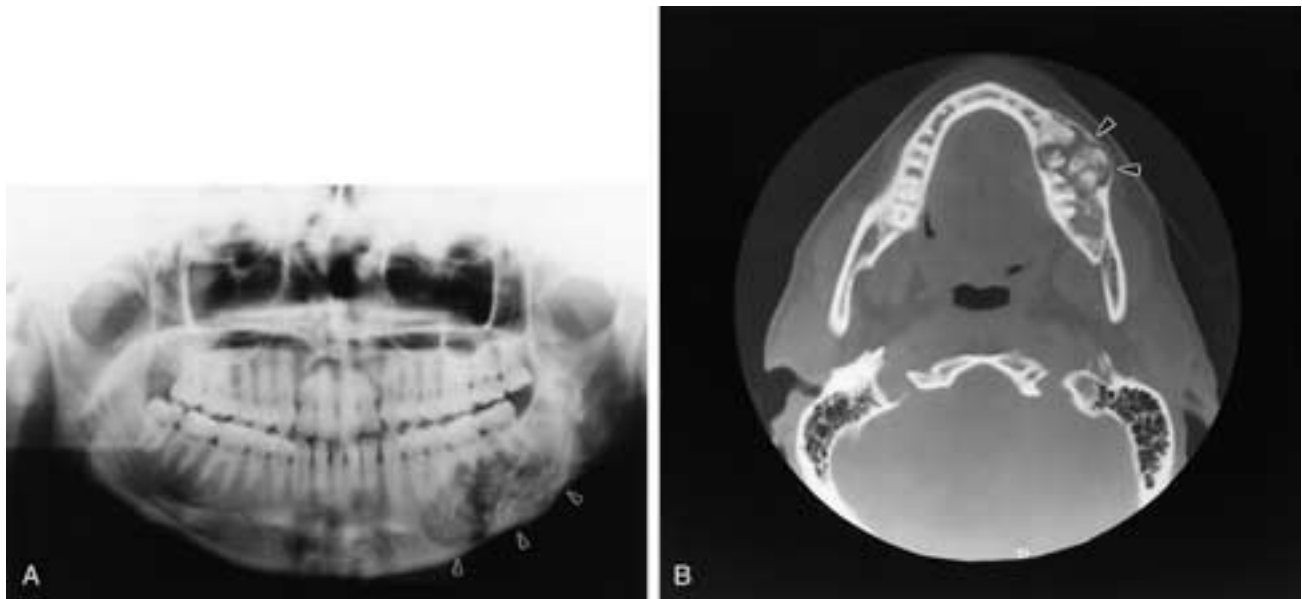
Cemento-ossifying fibroma in the mandible. A, Pantomogram shows a well-defined mixed radiolucent-radiopaque lesion (arrowheads). B, Axial CT (bone window setting) demonstrates a buccal expansile lesion with some calcifications in the mandible. The surrounding buccal bony cortex is barely preserved (arrowheads).
